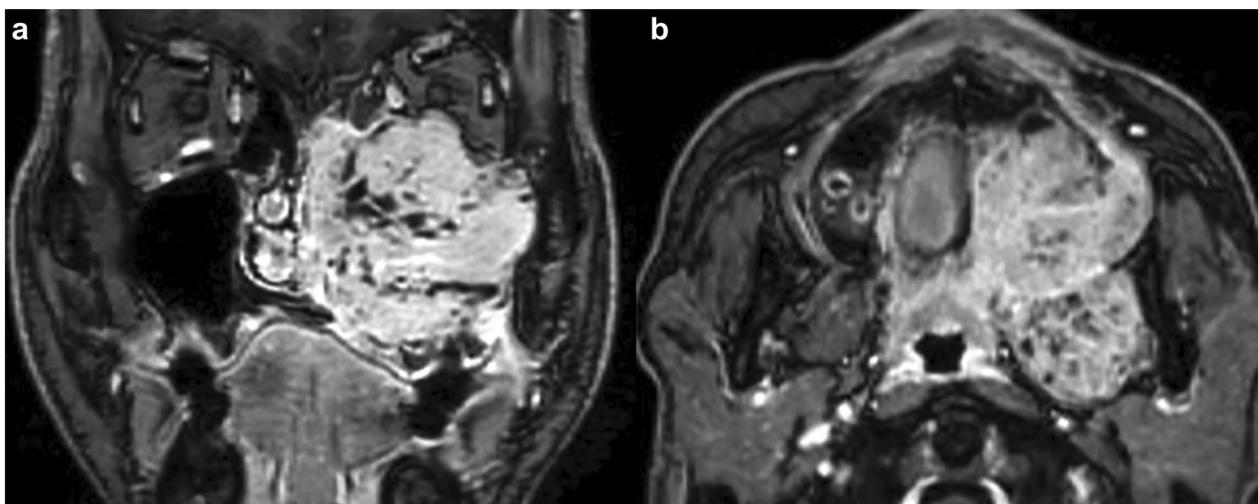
Images of case 2. Tumor destroys the left maxillary sinus and extends into the orbit. a Horizontal section of magnetic resonance imaging. b Coronal section of magnetic resonance imaging
